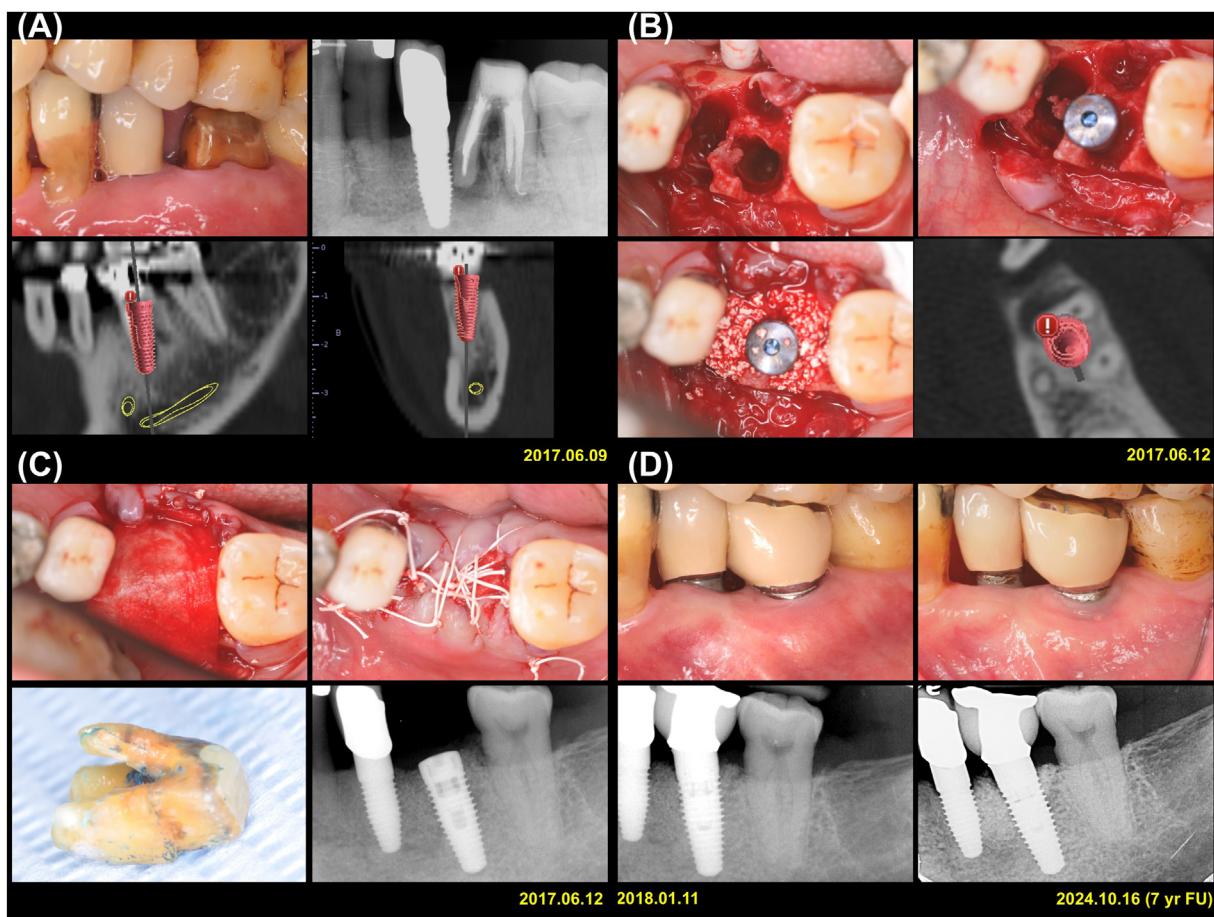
Clinical photographs and radiographs of our patient. (A) A 52-year-old male patient presented with a root fracture in a three-rooted mandibular first molar, rendering the tooth non-restorable and unsuitable for endodontic treatment. Cone beam computed tomography was used to evaluate factors such as special root morphologies, the presence of lingual concavities, proximity to the inferior alveolar canal, socket morphology and availability of sufficient interradicular septal bone. (B) After the careful extraction of the tooth, a type B socket was identified [4]. A pilot drill was used to access the center of the residual root septum, followed by the preparation of the implant bed. Subsequently, a cylindrical screw-type implant was immediately placed. The socket defect was then filled with alloplastic graft material and covered with a collagen membrane. (C) The interdental papillae were sutured with 4-0 polytetrafluoroethylene sutures for wound stabilization. (D) Six months later, the final crown was delivered. Clinical and radiographic evaluations at the 7-year follow-up showed healthy mucosa with minimal tissue recession and marginal bone loss.
